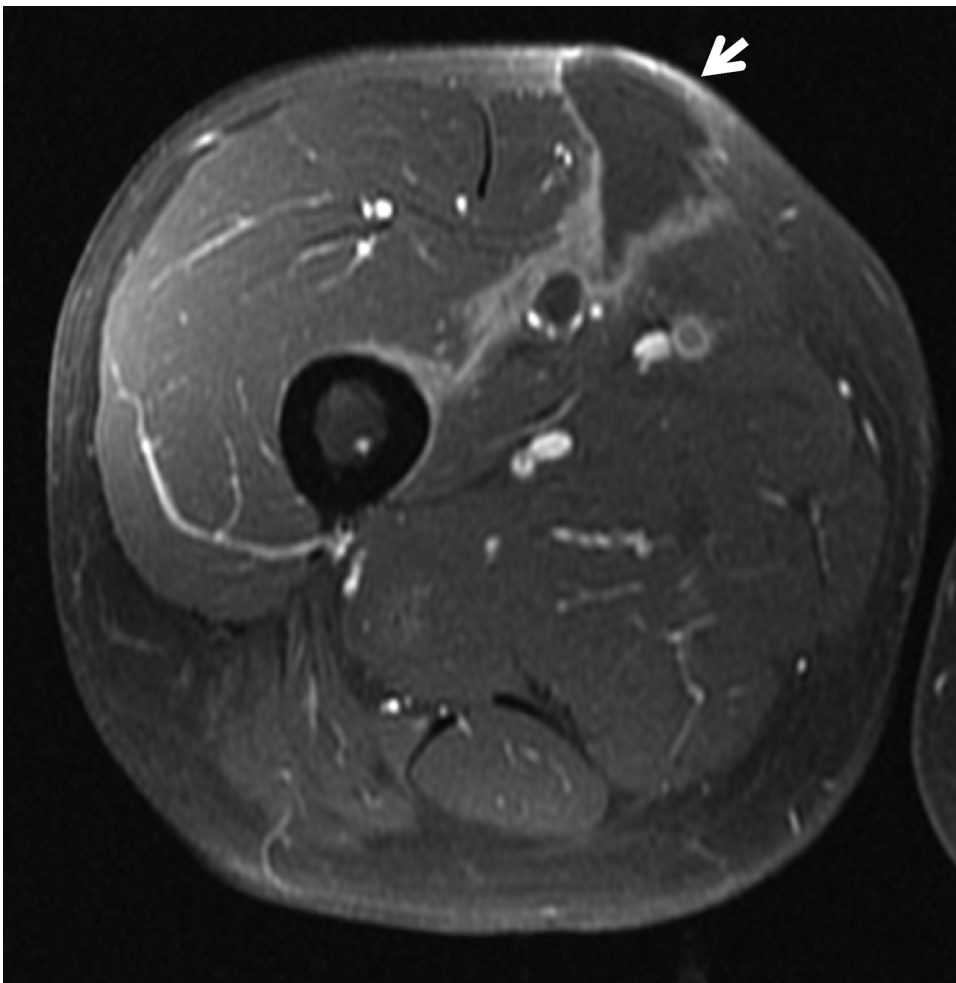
Axial T1-weighted MRI of the right thigh showing a cystic lesion (white arrow) involving the vastus medialis and vastus intermedius muscles and extending up to the dermis.
